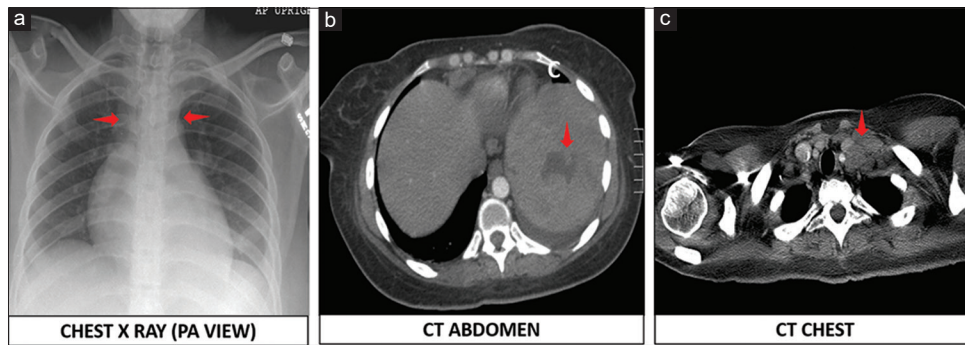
(a) Chest X-ray showing mediastinal fullness. (b) Transverse view of computed tomography pelvis showing hypoechoic lesion with splenomegaly. (c) Transverse view showing mediastinal lymph nodal enlargement
